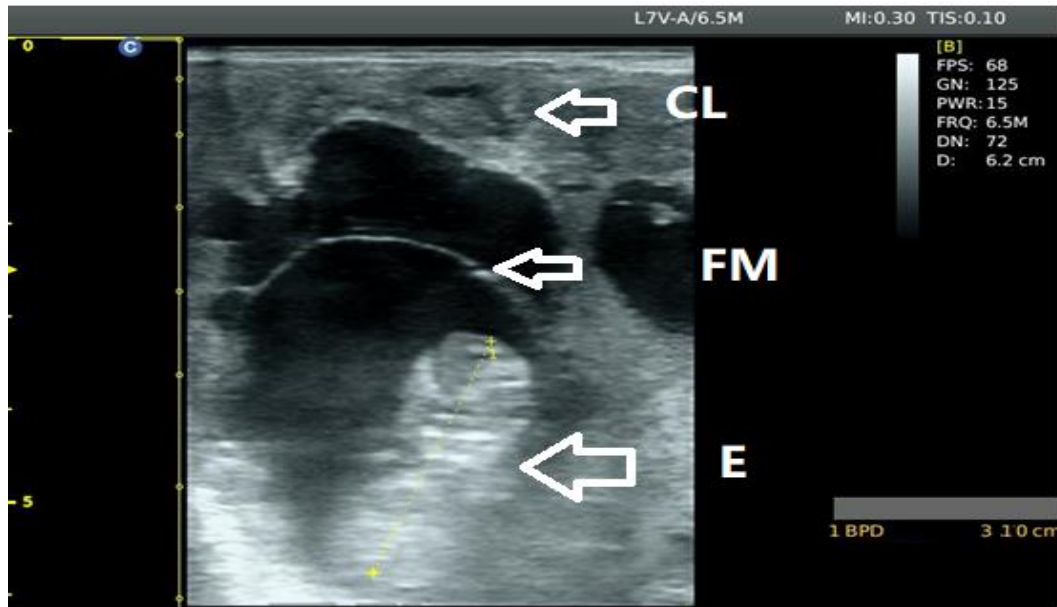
Transrectal Ultrasonography image showing gestational sac, fetal membrane (allanoic membrane) (FM) and corpus luteum (CL) on day 35 PM.
